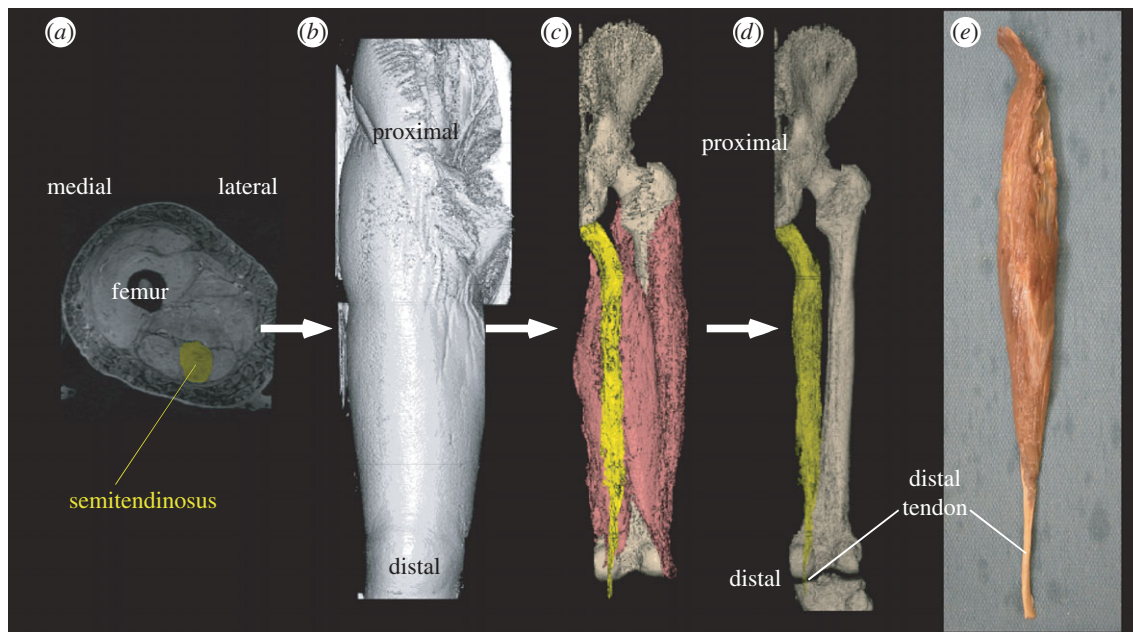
Magnetic resonance imaging (MRI) used to render and calculate muscle volume for a human semitendinosus (ST). (a) Serial contiguous slices are acquired in the transverse plane. ST is highlighted in yellow. (b) Serial images are registered to reconstruct the entire thigh. (c) Muscles are distinguished from other tissues to calculate total muscle volume. (d) ST muscle is isolated from the entire thigh and the PCSA calculated. (e) Comparative photograph of dissected human ST.
